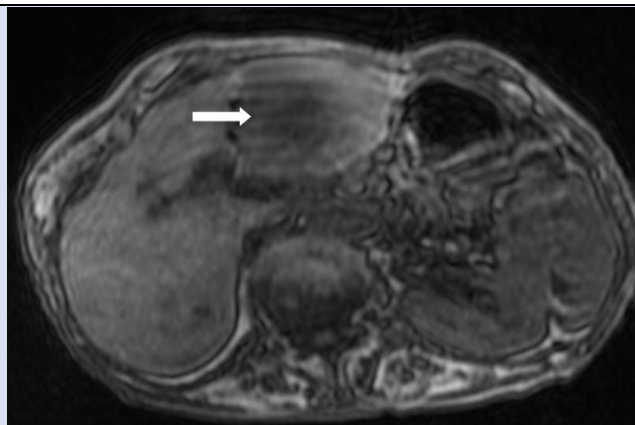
Abdominal MRI showing metastatic lesion in the left hepatic lobe.
